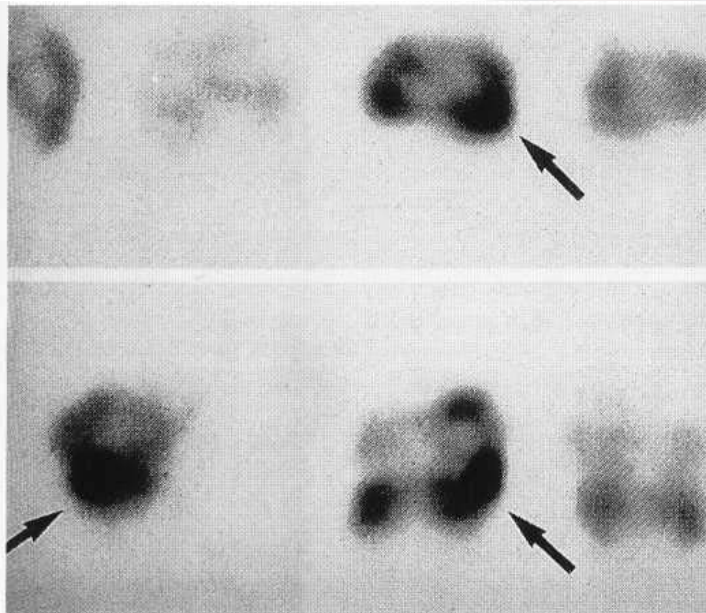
Radioisotope bone scan (SPECT) of the knee shows focal areas of increase in uptake (arrows) at sites of proven abnormality of the menisci. (Courtesy of Dr I. Fogelman.)
